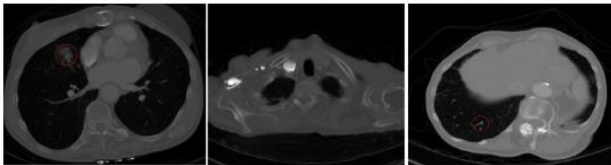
Different angles of CT lung cancer images.
